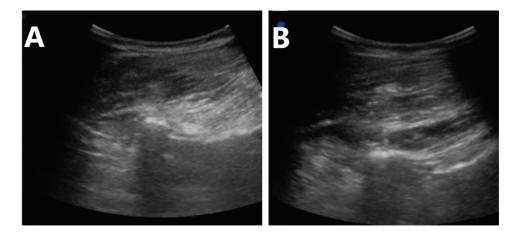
Ultrasound guided lumbar erector spinae plane block. Ultrasound scans: ESP block pre-injection (A) and post-injection (B).
